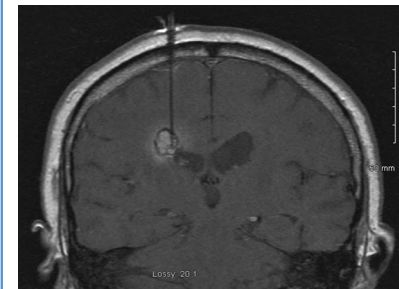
Representative T₁-weighted coronal magnetic resonance image demonstrating a laser-interstitial thermal therapy probe placed within a lesion just before thermal ablation.
